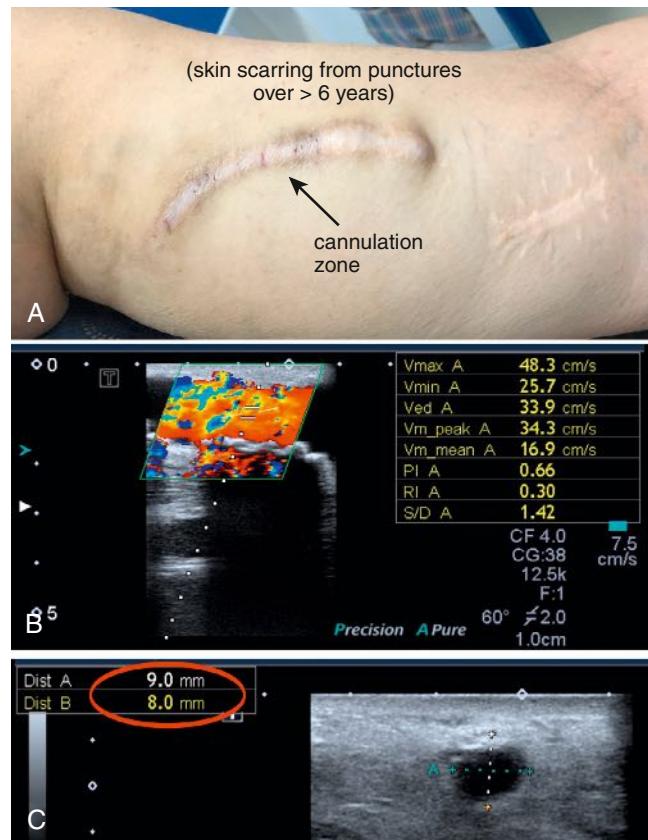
Ultrasound and computed tomography (CT) angiogram of human acellular vessel (HAV) from a patient from Poland (phase 2 study) who has been using the HAV for dialysis for 6 years. (A) Image of arm with HAV implant. The cannulation zone is indicated with a black arrow. Skin scarring occurred from approximately 6 years of dialysis. (B) CT angiogram of the HAV indicates patency. (C) Some degree of small dilation is noted, as the conduit diameter is 8 to 9 mm, slightly increased from the original 6-mm diameter.
